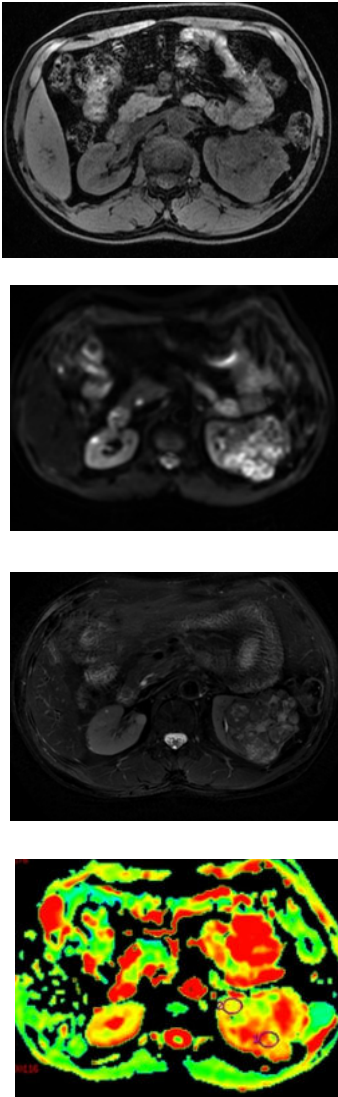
2Axial MRI images in a 65 year old male shows a lesion in left kidney which is Hypointense on T 1 W images and heterogeneously hyperintense on T 2 W images. (A,B). It shows diffusion restriction (C). ADC maps (D) showed the ADC value of lesion to be 1.44 × 10⁻³ mm²/sec (1) and uninvolved renal parenchyma (2) is 2.24 × 10⁻³ mm²/sec. On follow up lesion was proved to be clear cell type RCC.
